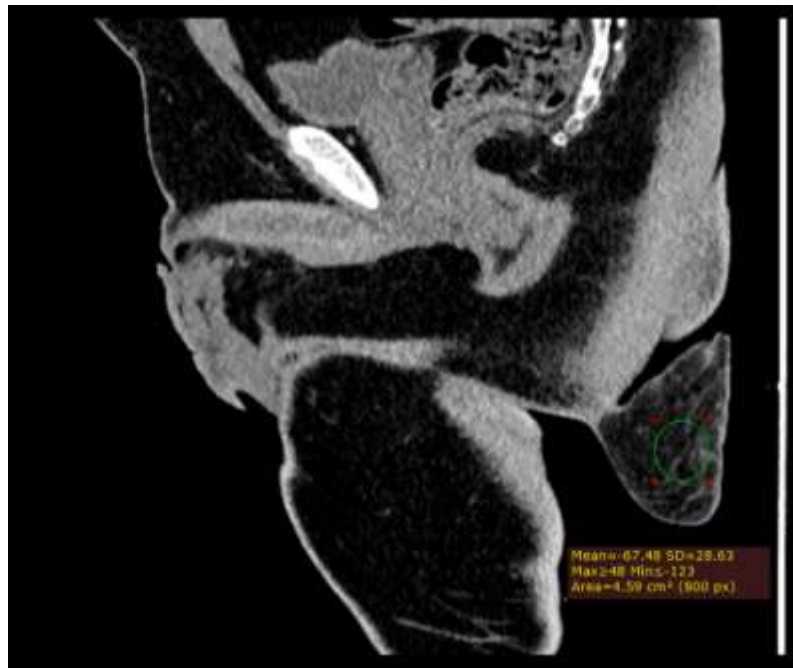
Computed tomography images, sagittal section shows a soft-tissue mass with the Hounsfield units (HU) value of - 67, consistent with fat density mass.
